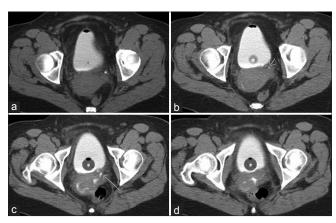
Computed tomography cystogram with intravenous contrast demonstrates the (a) left ureter proximal to fistula; (b) a slight narrowing of the distal left ureter; (c) a small fistula extending from the distal left ureter to the vagina; (d) extravasation of contrast
